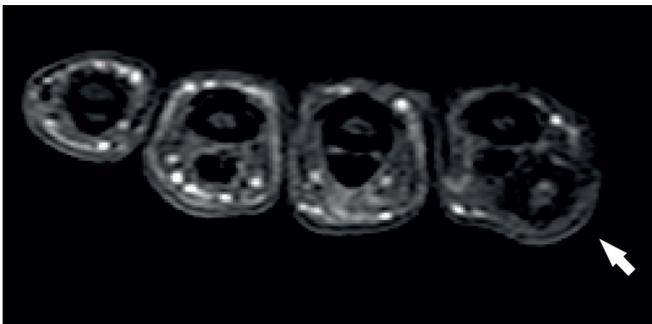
Axial plane MRI, a hypointense lesion digital nerve on T1 weighted fat suppression series (white arrow).
